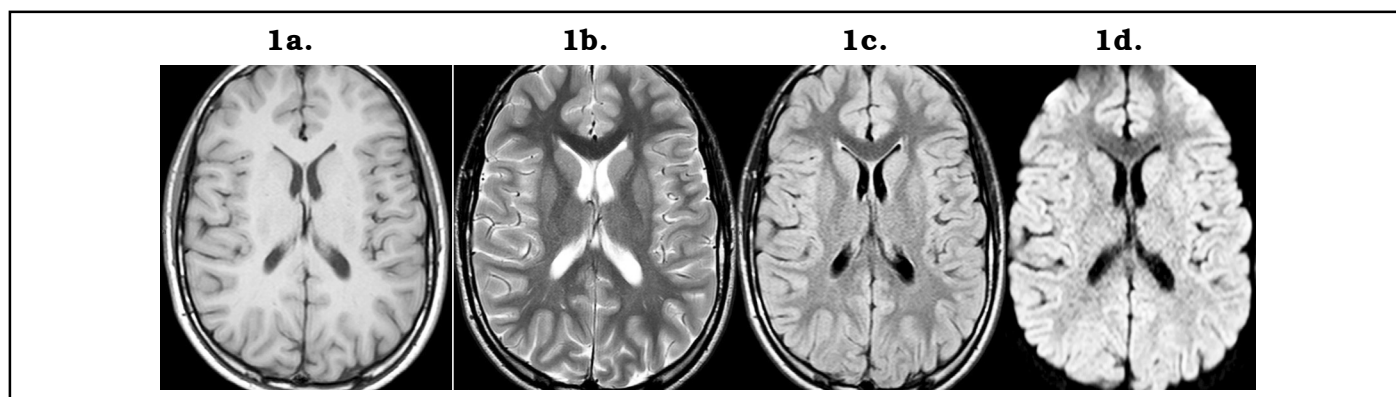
(1a to 1d): Normal MR imaging pattern in 2 yr old children
